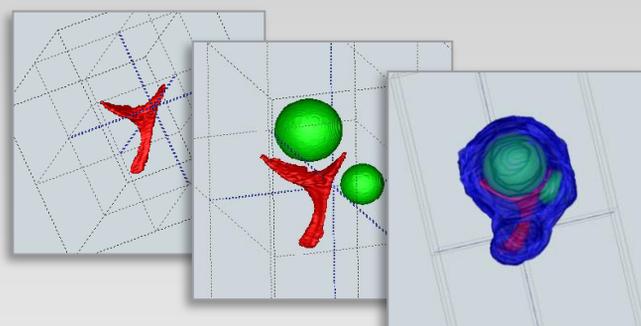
Process of segmentation from MRI images with identification of endometrial cavity, uterus and myomas.
